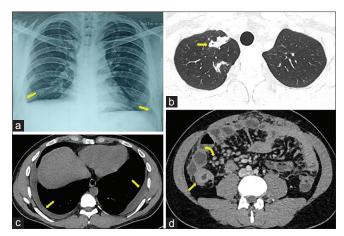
Radiological images of thorax and abdomen. Frontal radiograph (a) in standing position shows bilateral pleural effusion (R > L); computer tomography images through the lung apex shows fibrotic (b) changes (arrow) of both lungs with mild surrounding ground glass changes in the left anterior segment (not shown), bilateral empyema with subtle enhancing walls (c), short segment enhancing (d) mural thickening at the ileocecal junction (arrow) and multiple discrete enhancing lymph nodes in right iliac fossa and mesentery of central abdomen (curved arrow)
